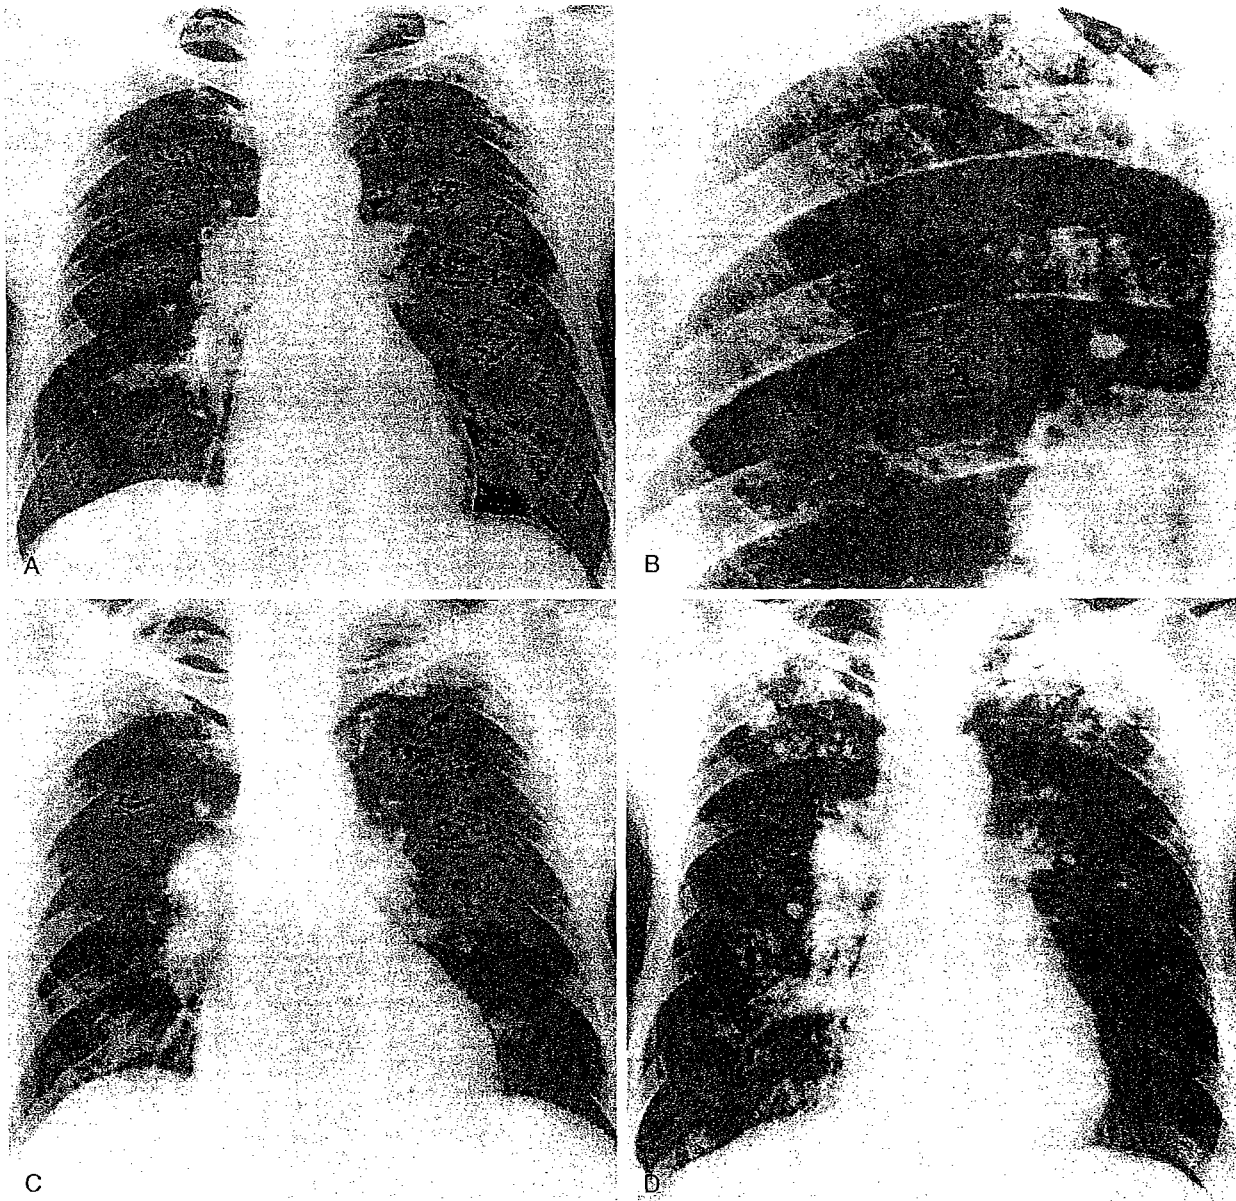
Silicosis Progressing from Simple to Conglomerate. A 54-year-old foundry worker was asymptomatic at the time of the first radiograph (A). The opacities throughout both lungs are predominantly small and rounded and are more evident in the upper and mid zones than in the bases. The nodules are relatively discrete, as revealed in a magnified view of the right upper lung (B). An exceptional degree of hilar lymph node enlargement is present bilaterally. Four years later (C), the nodules are more numerous and have become confluent in the subapical zones bilaterally so as to form shadows of homogeneous density (conglomeration). A radiograph (D) taken 7 years after C reveals marked progression of the disease; not only are the nodules more numerous, but their density is considerably greater than had been observed earlier. By this time, confluence of shadows in the subapical zones had progressed considerably; one on the left had undergone cavitation (arrow).
